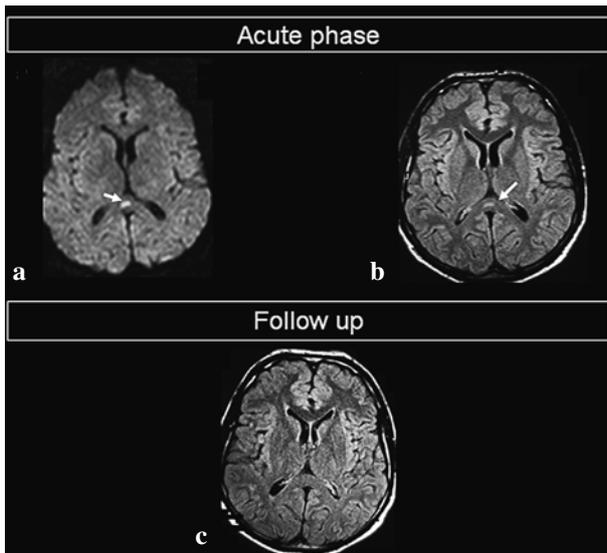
Magnetic resonance imaging scan performed 3 days after symptoms onset, showing an ovoid abnormality of the splenium of the corpus callosum, hyperintense in diffusion weighted sequences (arrow) (a), with decreased ADC values (not shown), and hyperintense on FLAIR sequences (arrow) (b).
